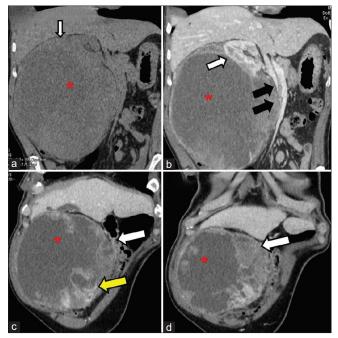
(a) Plain computed tomography scan shows the mass abutting the inferior surface of the liver and occupying the entire right subhepatic with necrosis (*). (b) The mass encasing and displacing the right kidney (white arrow) and splaying the adjacent renal vein and inferior vena cava (black bold arrows) with necrosis (*). (c) Displacement of ascending colon and hepatic flexure (white arrow). The mass shows necrosis (*) and peripheral enhancing nodular soft tissue (yellow arrow). (d) Peripheral soft-tissue component (white arrow) on the delayed and equilibrium phase of the dynamic computed tomography study with central liquefaction (*)
